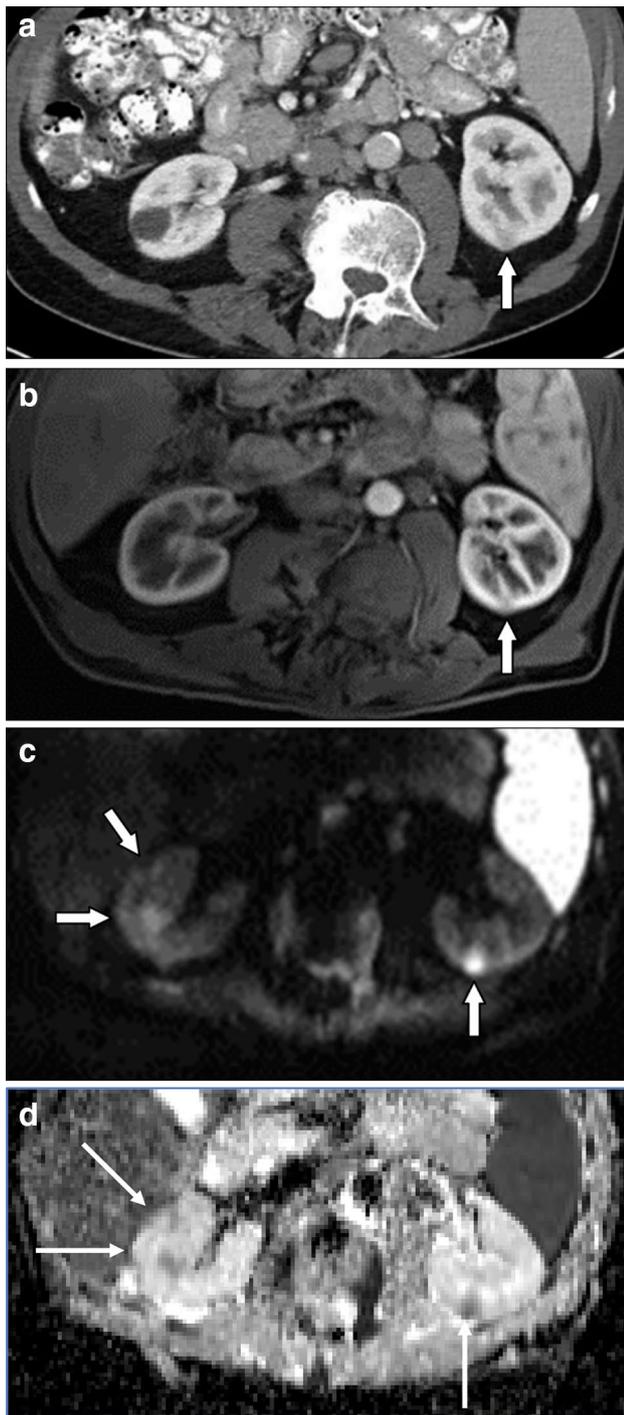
Lymphomatous involvement of the kidney in a 68-year-old man, best seen on DWI. a CECT demonstrates a 1.2 cm lesion in the posterior aspect of the left kidney suspicious for solid mass (arrow). MRI redemonstrates this solid lesion in the posterior left kidney on axial contrast-enhanced T1 FS (b, arrow). Numerous additional small renal parenchymal lymphomatous lesions are better seen on DWI than on conventional sequences (arrows), hyperintense on B800 (c), hypointense on ADC (d)
